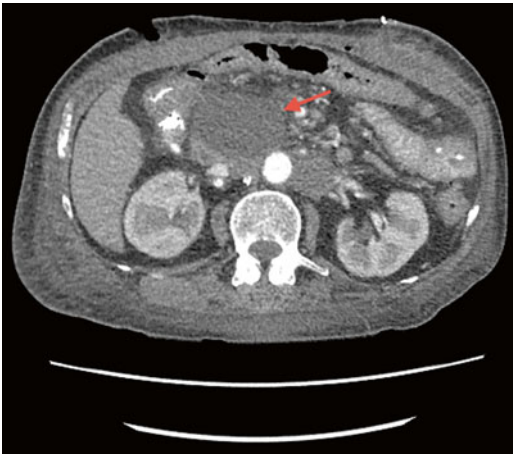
A CT scan demonstrates a hypodense mass in the pancreatic head (*arrow*). This lesion is due to chronic pancreatitis and resolved on subsequent imaging tests
